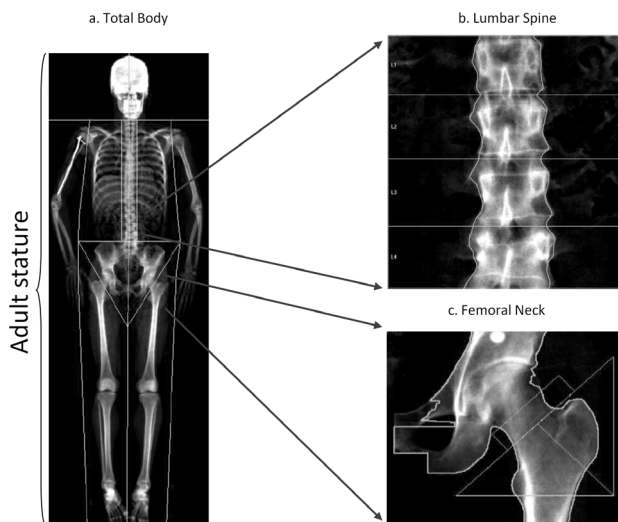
Dual energy X-ray absorptiometry (DXA) images of A) Total Body, B) Lumbar Spine and C) Femoral Neck. The latter two sites are usually studied for the diagnosis of osteoporosis. The measurement of stature (height) is depicted in A).
